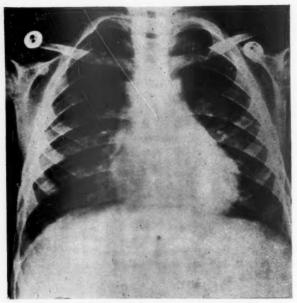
Radiograph of the heart before operation.
